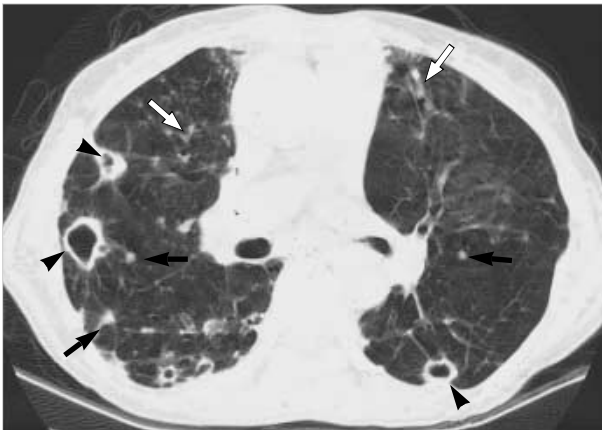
A 69-yr-old woman with *M. avium-intracellulare* complex pulmonary disease. Transaxial thin-section (2.5-mm thickness) CT scan obtained at level of bronchus intermedius shows multiple cavitory nodules (arrowheads) in both lungs. Also note small nodules (arrows) and bronchiectasis (white arrows).
